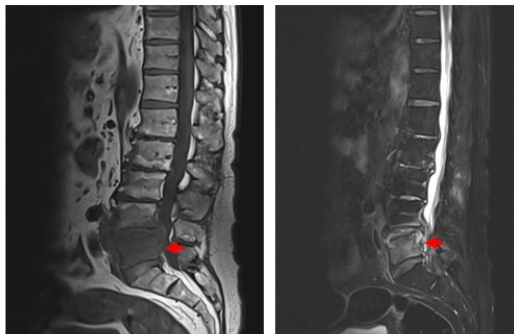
L-spine MRI showed T1 low signal and intermediate to high signal on T2WI and total enhancement after contrast infusion at L5 vertebra body, suggesting spondylodiscitis in L5. (red arrow).
